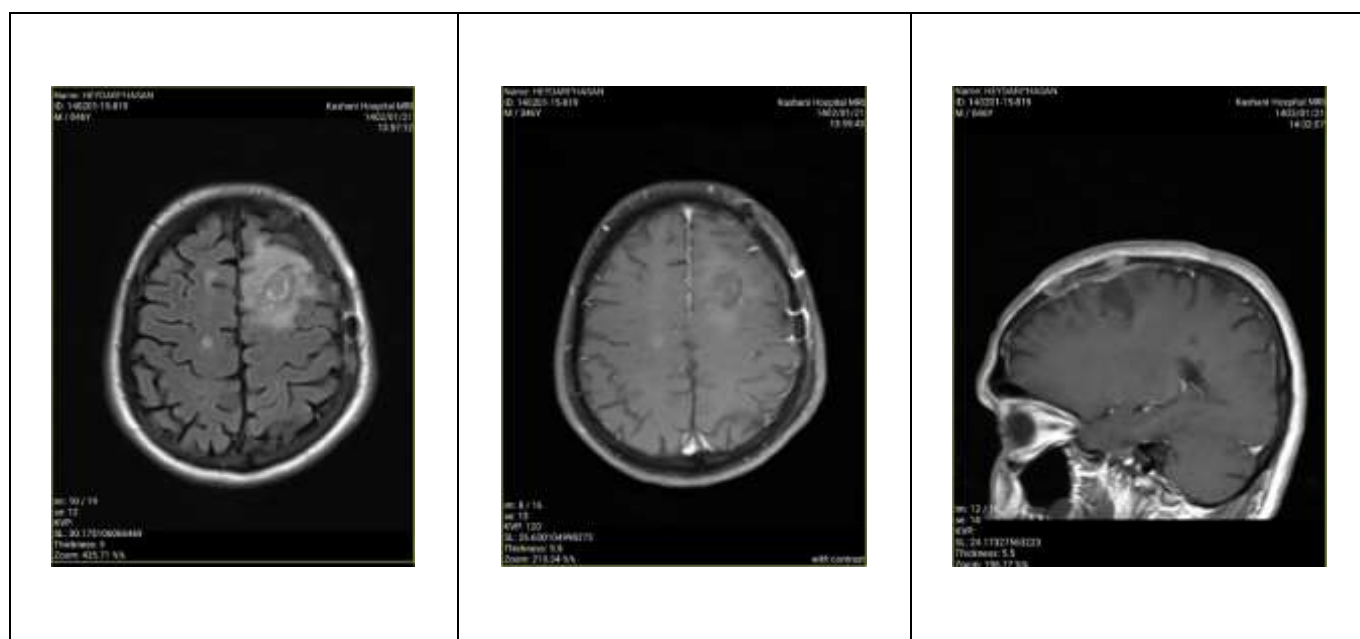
CT scan of the brain (parietal lobe tumor)
